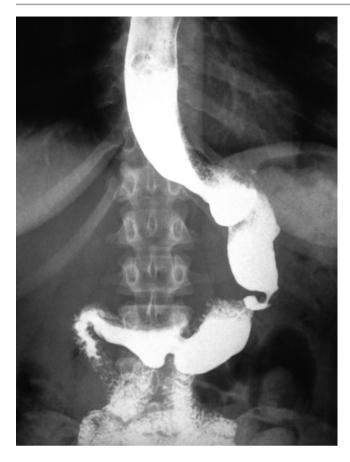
X-Ray image showing gastric twist twists
